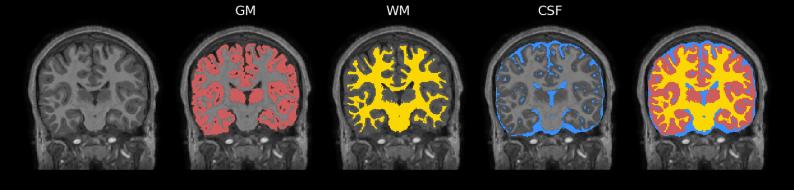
An example of the results obtained with Neurocloud-VOL on the brain segmentation in GM, WM and CSF tissues from T1-weighted MRI.
